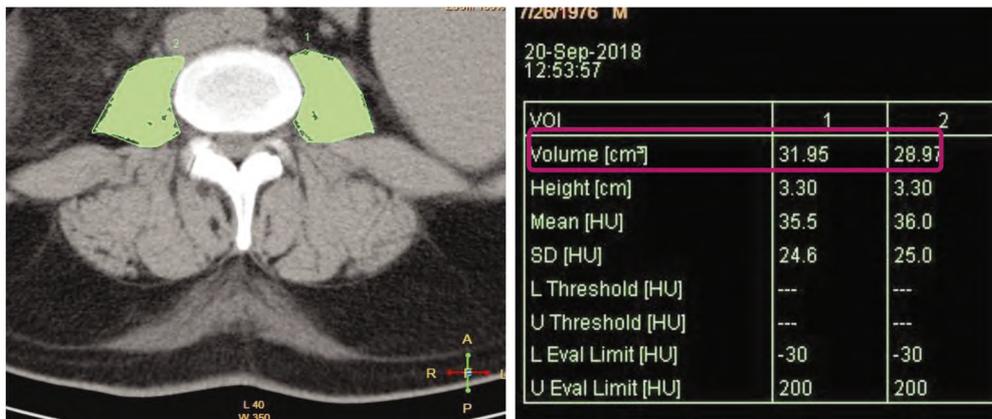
CT psoas muscle volume which
